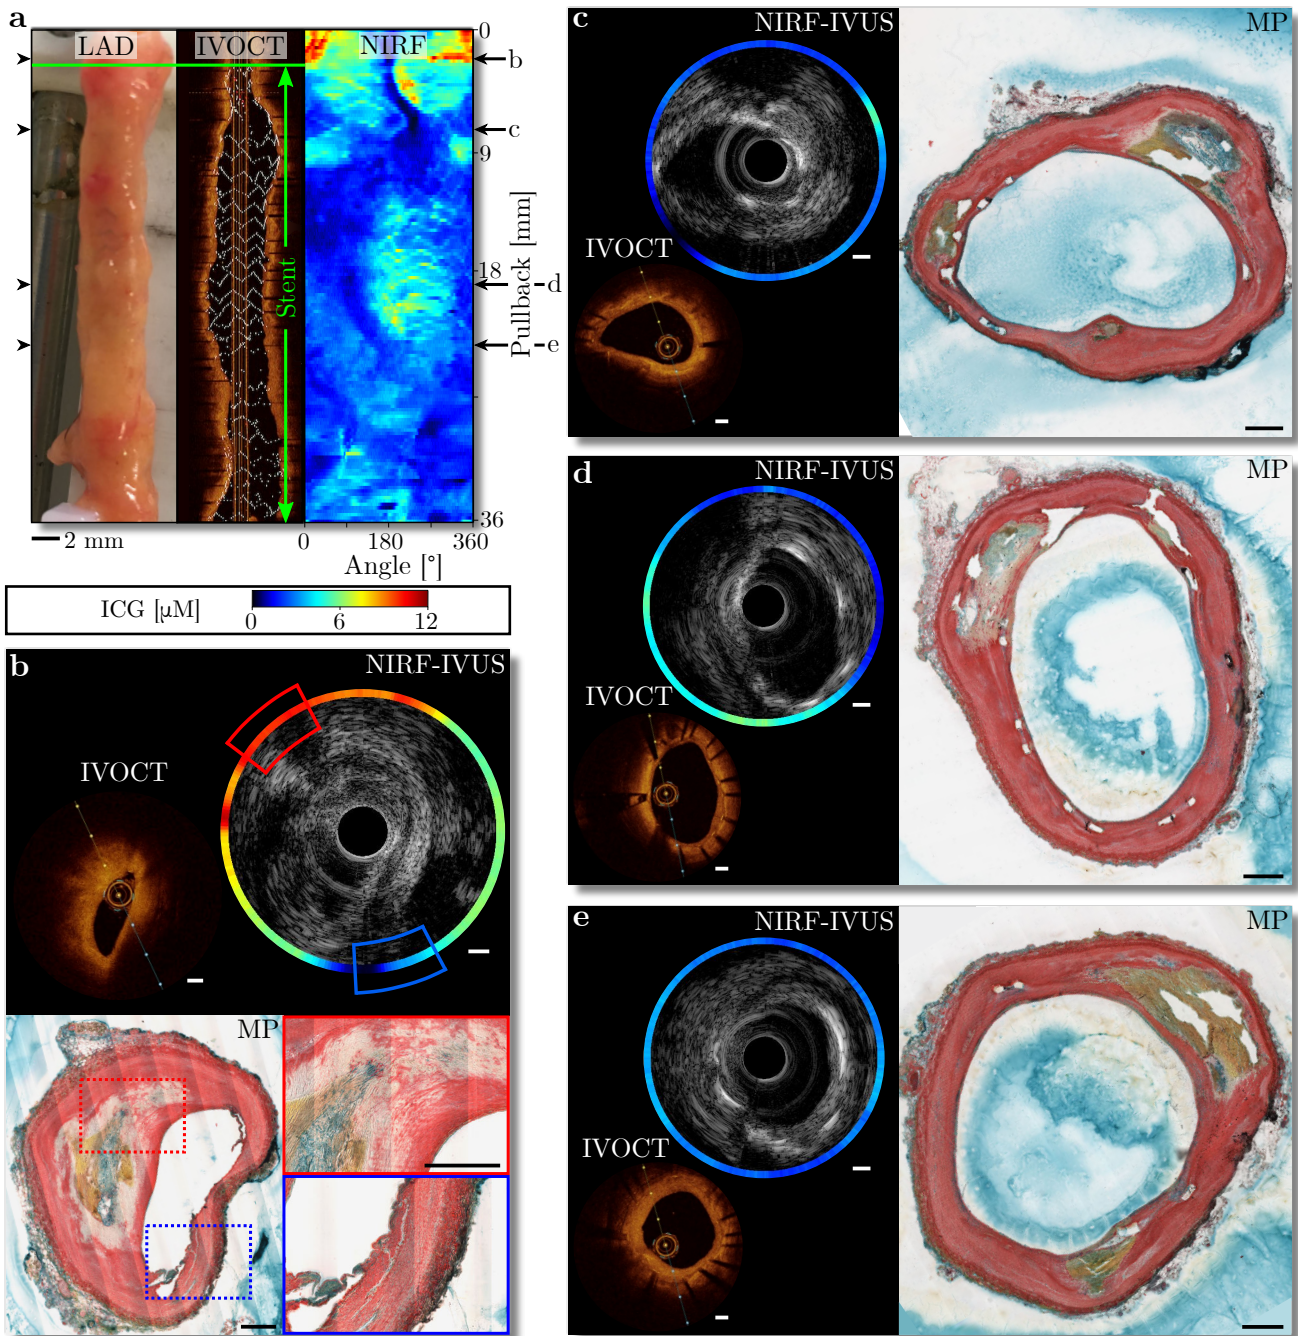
Intravascular NIRF-IVUS imaging of an ICG-perfused coronary artery detects high ICG concentration in plaque area and low ICG concentrations in stented tissue regions. a - Picture and corresponding IVOCT and NIRF map of an ICG-perfused LAD indicating stented tissue region between the pullback positions 3mm and 36mm; b - High ICG concentration detected with NIRF-IVUS (Red box) in plaque area (MP – Red box) in contrast to low ICG concentration (Blue box) detected in healthy tissue region (MP – Blue box); c-e - Low ICG concentration detected with NIRF-IVUS in stented tissue regions; In all panels: NIRF: Near-infrared Fluorescence; IVUS: Intravascular Ultrasound; IVOCT: Intravascular OCT; MP: Movat Pentachrome; ICG: Indocyanine Green; Scale bars: 500 μm .
